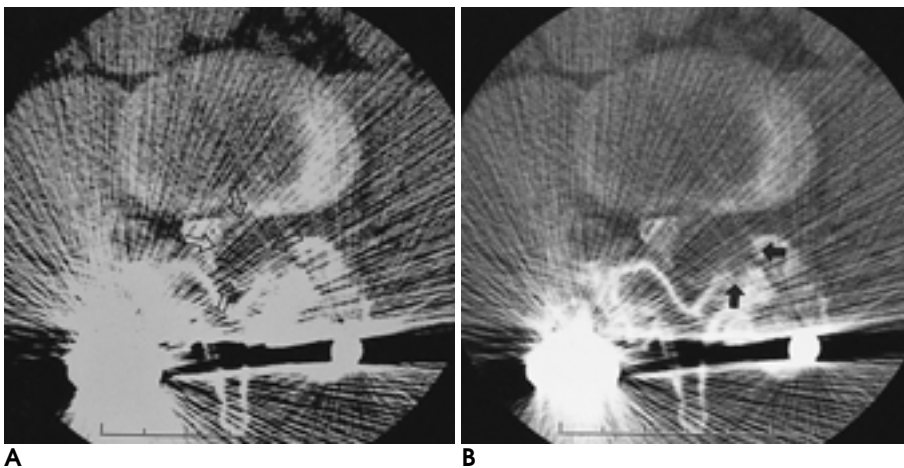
Post-myelogram CT shows left-sided extradural soft-tissue mass(arrows) at the level of L4-5 disc space displacing the thecal sac(A). Note bony erosion of the left facet joint on bone setting(arrows on B).
